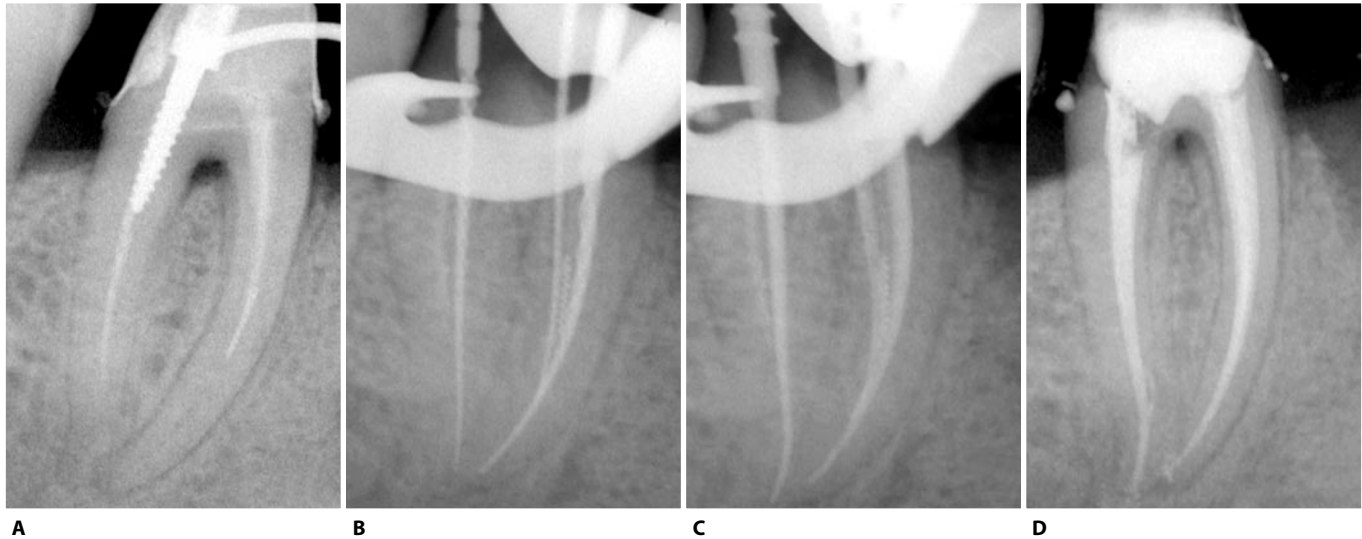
A. Retreatment of a lower right first molar with a screw post in the distal root and a broken instrument in the mesial root. B. Once the screw post has been removed the instrument in the mesial root is by-passed and a working length radiograph is taken. The two mesial canals are confluent between the middle third and apical third. Radiograph with Thermafil verifiers. C. In the presence of merging root canals one must choose an obturator to insert at the working length and a second obturator to insert up to the point of convergence. Since the mesial root is delicate and fine it is preferable to by-pass the fragment which will then be incorporated in the mass of warm gutta-percha. D. Post operative radiograph. While the main canal is obturated (that is the canal in which the obturator will reach the working length) it is advisable to insert a carrier or a metal verifier in the second canal so as to avoid the reflux of gutta-percha resulting in the loss of hermeticity of the obturation.
